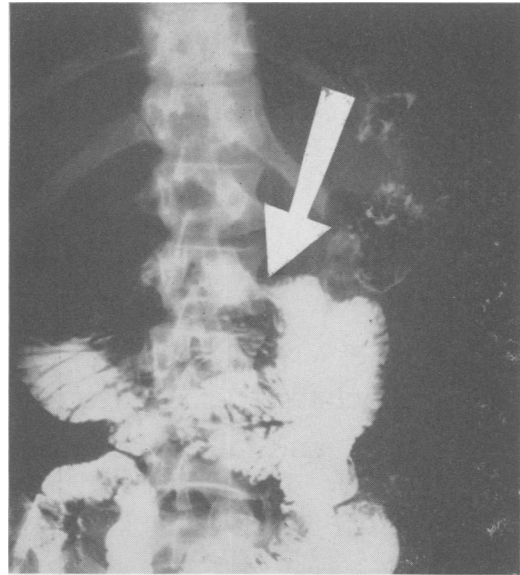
Upright preoperative gastro-intestinal x-ray. Arrow indicates point interpreted by radiologist as level of duodeno-jejunal angle at the mid second lumbar vertebral body.
